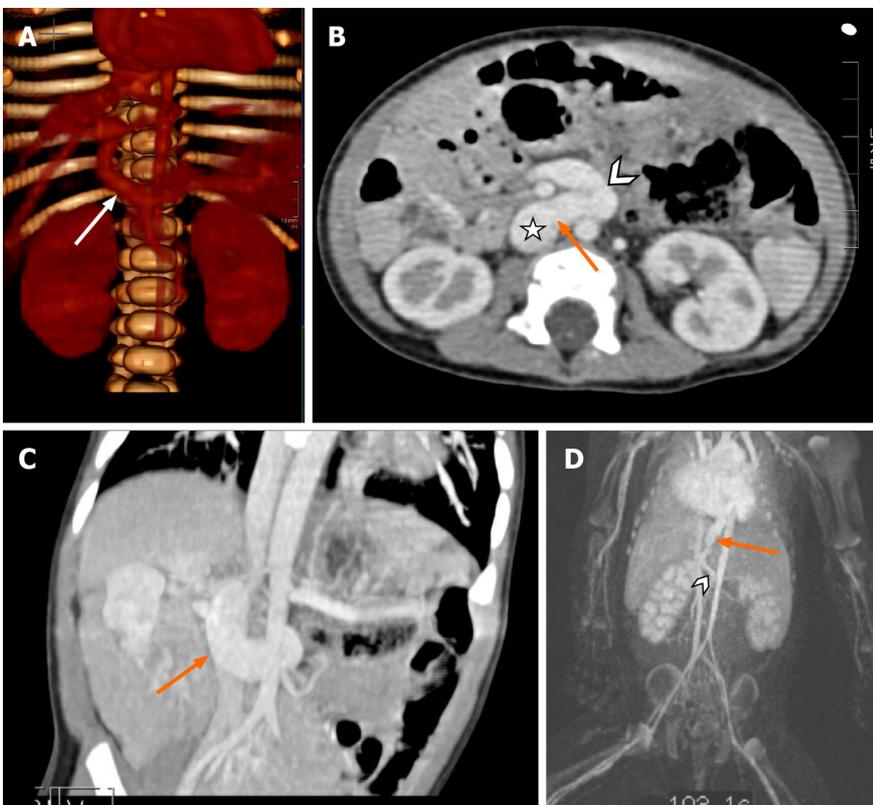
Examples of congenital extrahepatic portosystemic shunts. A: Nineteen-month-old with congenital extrahepatic porto-systemic shunts (CEPSS) Type II. Connection (arrow) of portal vein to inferior vena cava (IVC). Reconstruction 3D rendering of a computed tomography scan; B and C: One year old with a history of heterotaxia, intestinal malrotation, pulmonary arteriovenous malformations and CEPSS Type II (orange arrow), portal vein (chevron) to IVC (star); D: Type II extrahepatic shunt superior mesenteric vein (chevron) and shunt (arrow) draining directly into the right atrium.
